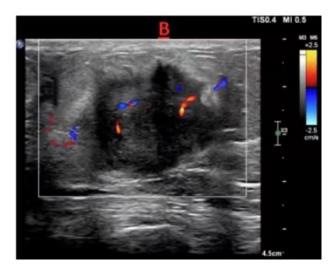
Ultrasonographic evaluation of breast. (A) A 2-dimensional ultrasound image showing a solitary mass in the right breast with a size of approximately $3.7 \times 3.6 \times 2.7$ cm, an irregular shape, a "crab-like" change, fuzzy edges, and burrs. The internal echoes were uneven, and hypoecho and spot-like strong echoes were observed. (B) Color Doppler flow imaging (CDFI) showed abundant blood flow signal within the tumor, with a Resistance index (RI) of 0.8. The diagnostic outcomes of color Doppler ultrasound indicated Breast Imaging-Reporting and Data System (BI-RADS) level 5.
